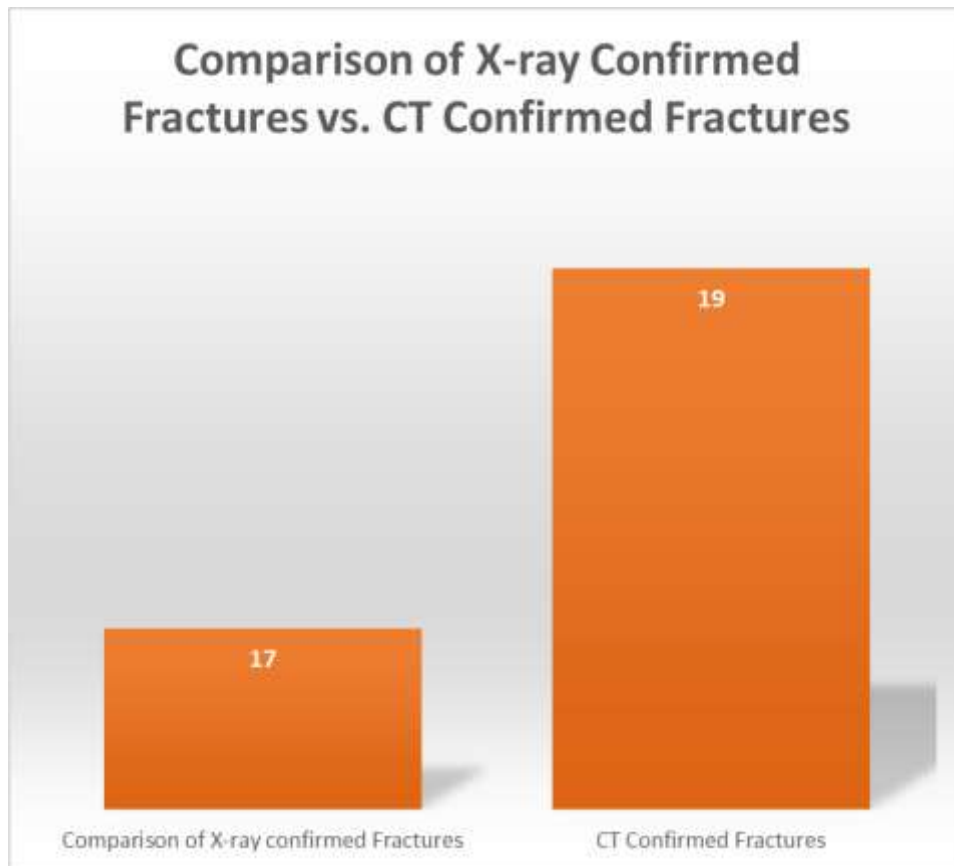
COMPARISON OF X-RAY REPORTED FRACTURES VS. CT CONFIRMED FRACTURES (n = 31)
